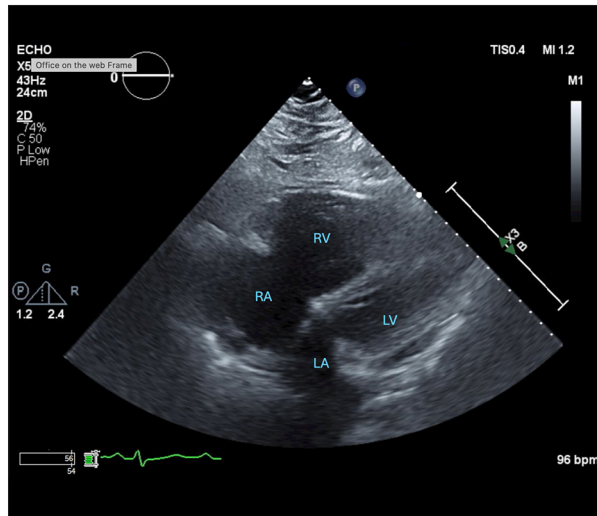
Transthoracic echocardiography (subcostal view) demonstrates right ventricular enlargement with an increased RV/LV ratio, reflecting right ventricular dilation that exceeds the size of the left ventricle. Additionally, the right ventricular wall appears thickened, suggesting chronic pressure overload and compensatory remodeling. These findings are indicative of significant right-sided volume or pressure overload and suggest advanced right ventricular remodeling.
